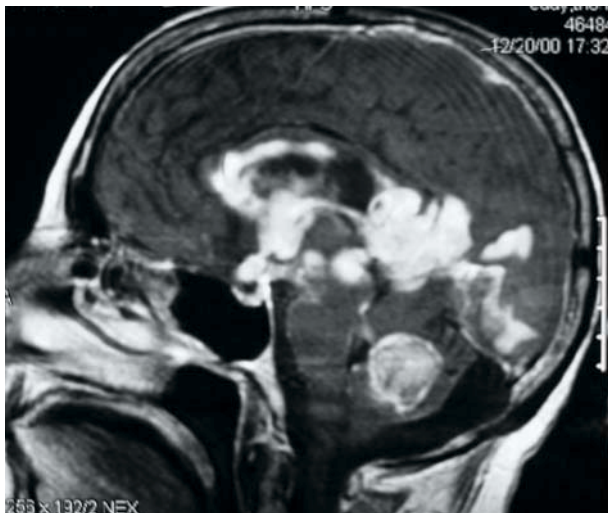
Sagittal T1-weighted MRI with contrast revealing diffuse infiltrating glioma of the supratentorial, infratentorial compartments and meningeal dissemination
